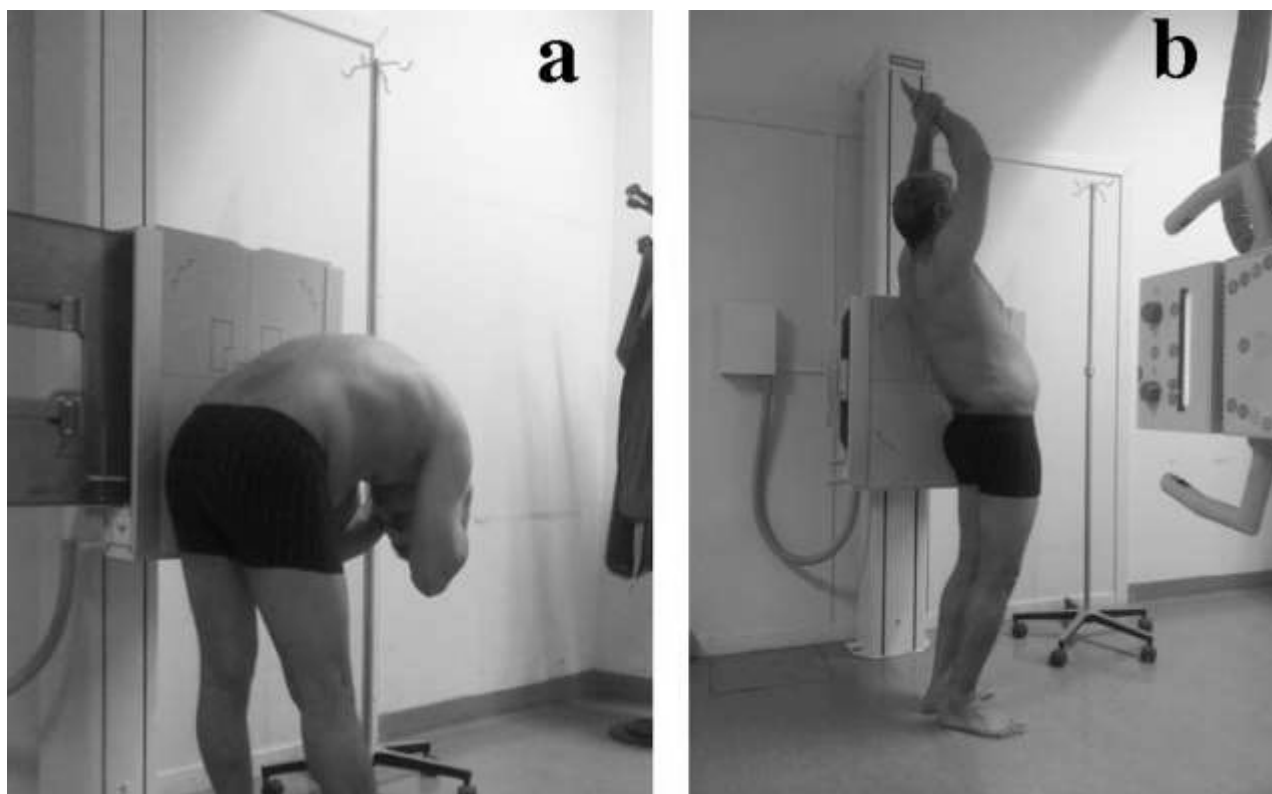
A patient during a radiographical examination. The patient was asked to bend the upper body back and forward as much as possible.
